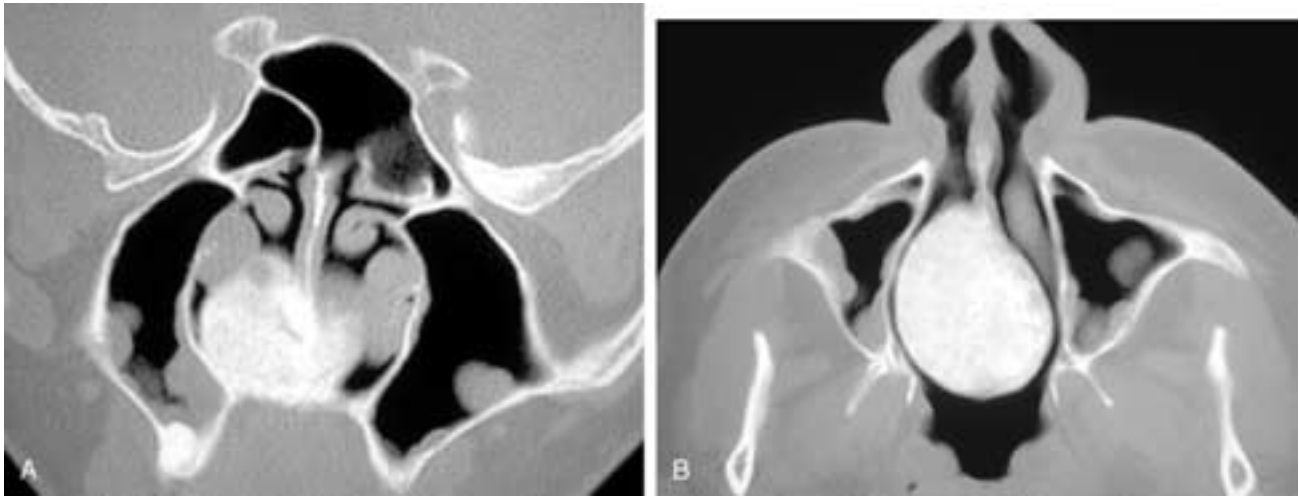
Coronal (A) and axial (B) CT scans show a densely ossified mass in the nasal septum. Two months earlier, this was a nonossified mass. This patient had a healed brown tumor from hyperparathyroidism.
